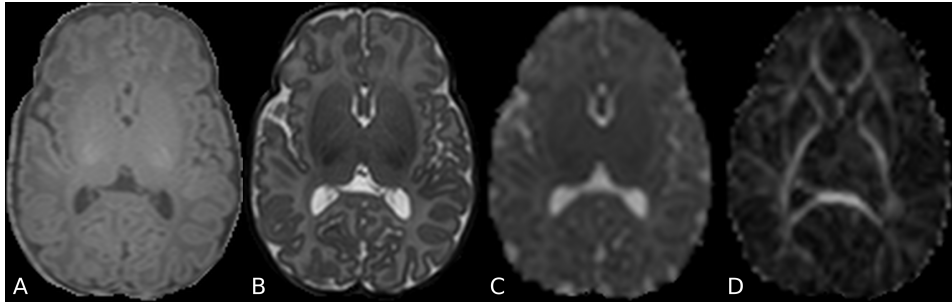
Structural imaging of the neonatal brain. T1-weighted image (A), T2-weighted image (B), ADC map (C) and FA map (D) of a neonatal brain (skull-stripped) acquired at 44 weeks post-menstrual age (PMA) are presented.
